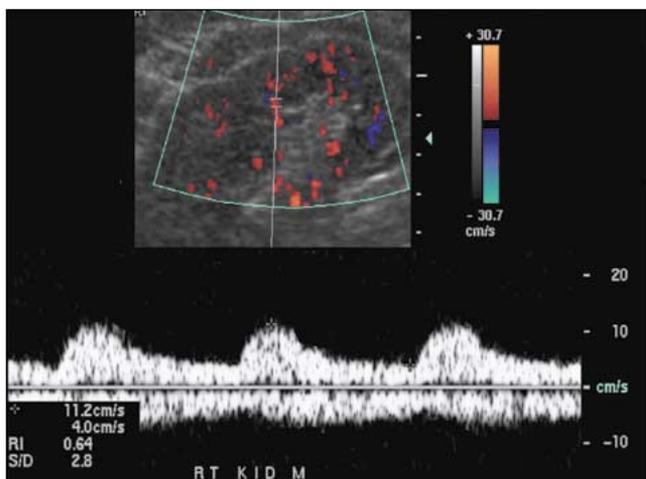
A, Tardus-parvus waveforms in a patient with RA stenosis (same patient as in Fig 8). Note the delayed and dampened upstroke, yielding a rounded appearance to the waveform. B, Doppler spectra from the same patient, immediately after angioplasty, show a normal appearance. Note the return of a rapid systolic upstroke and a well-defined ESP.
